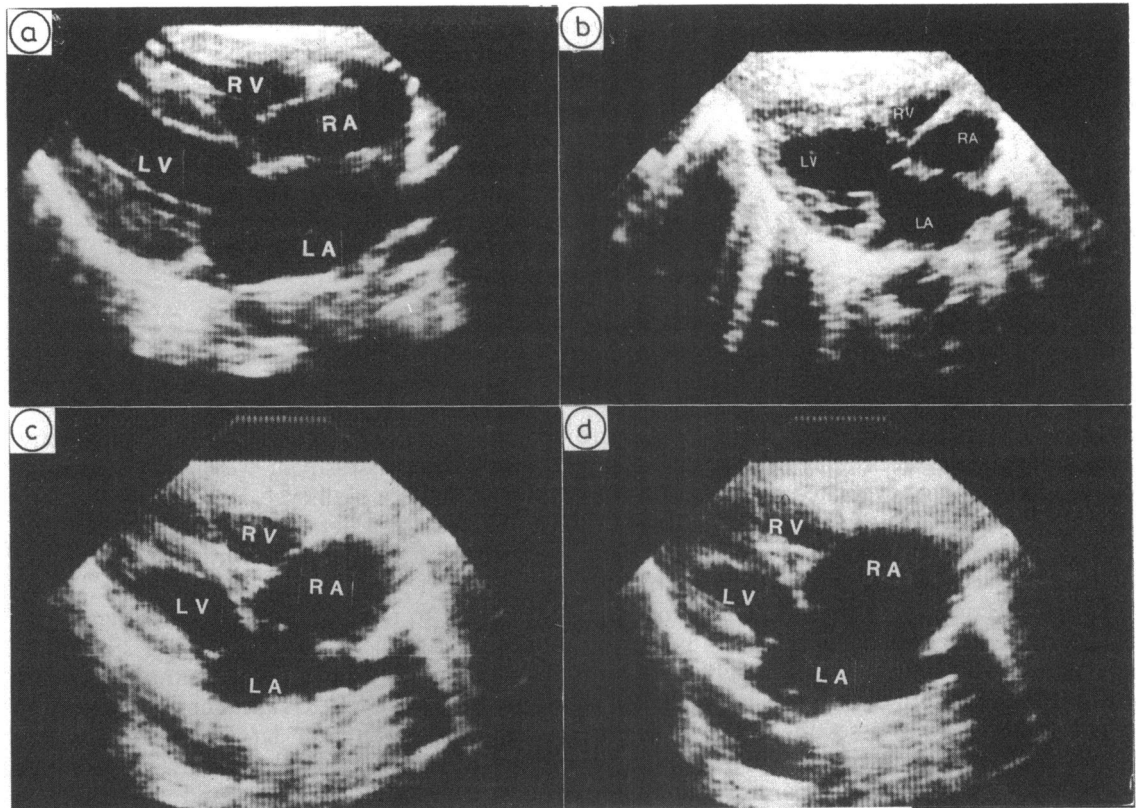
Echocardiographic grading of the atrial septum from the subcostal position as intact (a), or showing a small (b), moderate (c), or large (d) defect.
